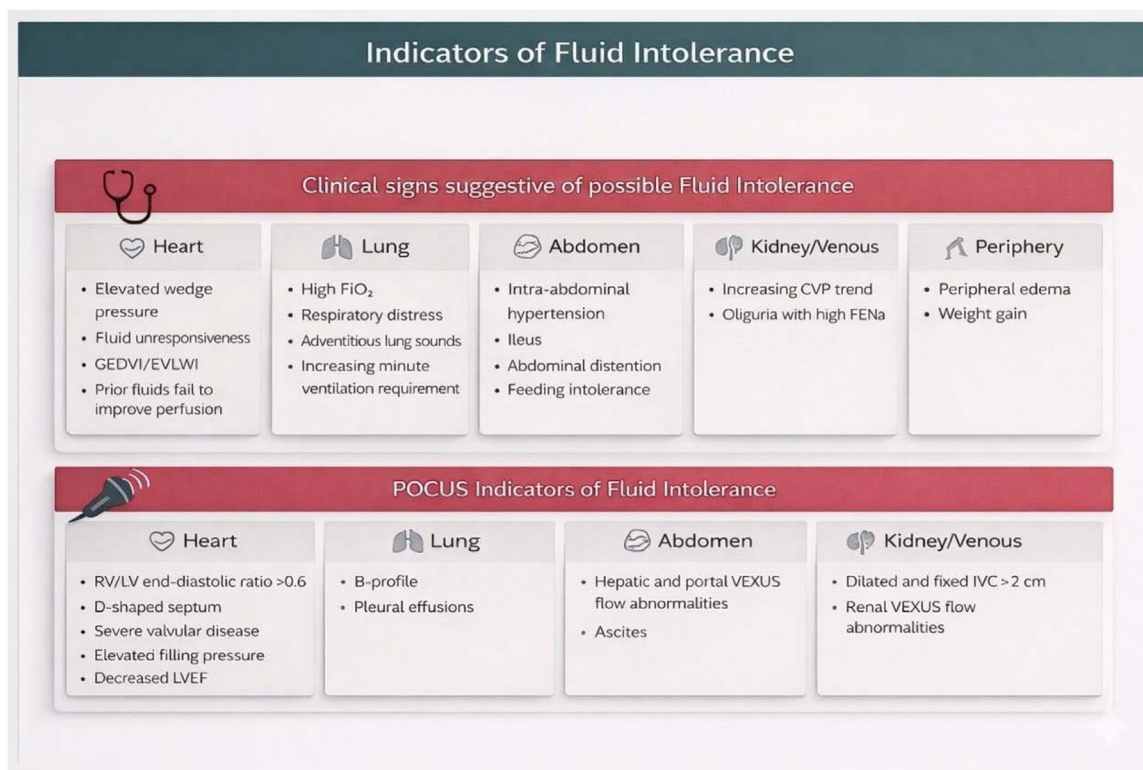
Common examples of clinical and point-of-care ultrasound (POCUS) findings that may suggest reduced tolerance to further fluid administration, grouped by organ system. Findings should be interpreted in the overall clinical and hemodynamic context. RV: Right ventricle; LV: Left ventricle; LVEF: Left ventricular ejection fraction; LA: Left atrium; FENa: fractional excretion of sodium; GEDVI global end diastolic volume index (PiCCO-device) EVLWI: extravascular lung water index; IVC: inferior vena cava; VExUS: Venous Excess Ultrasound Score; CVP: central venous pressure.
